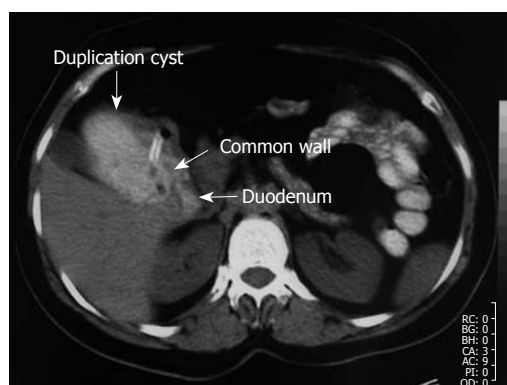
Oral and intravenous contrast-enhanced abdominal CT imaging. The nasogastric tube was extended into the cyst, which was filled with oral contrast medium, through the defect between the duodenum and the cyst.
